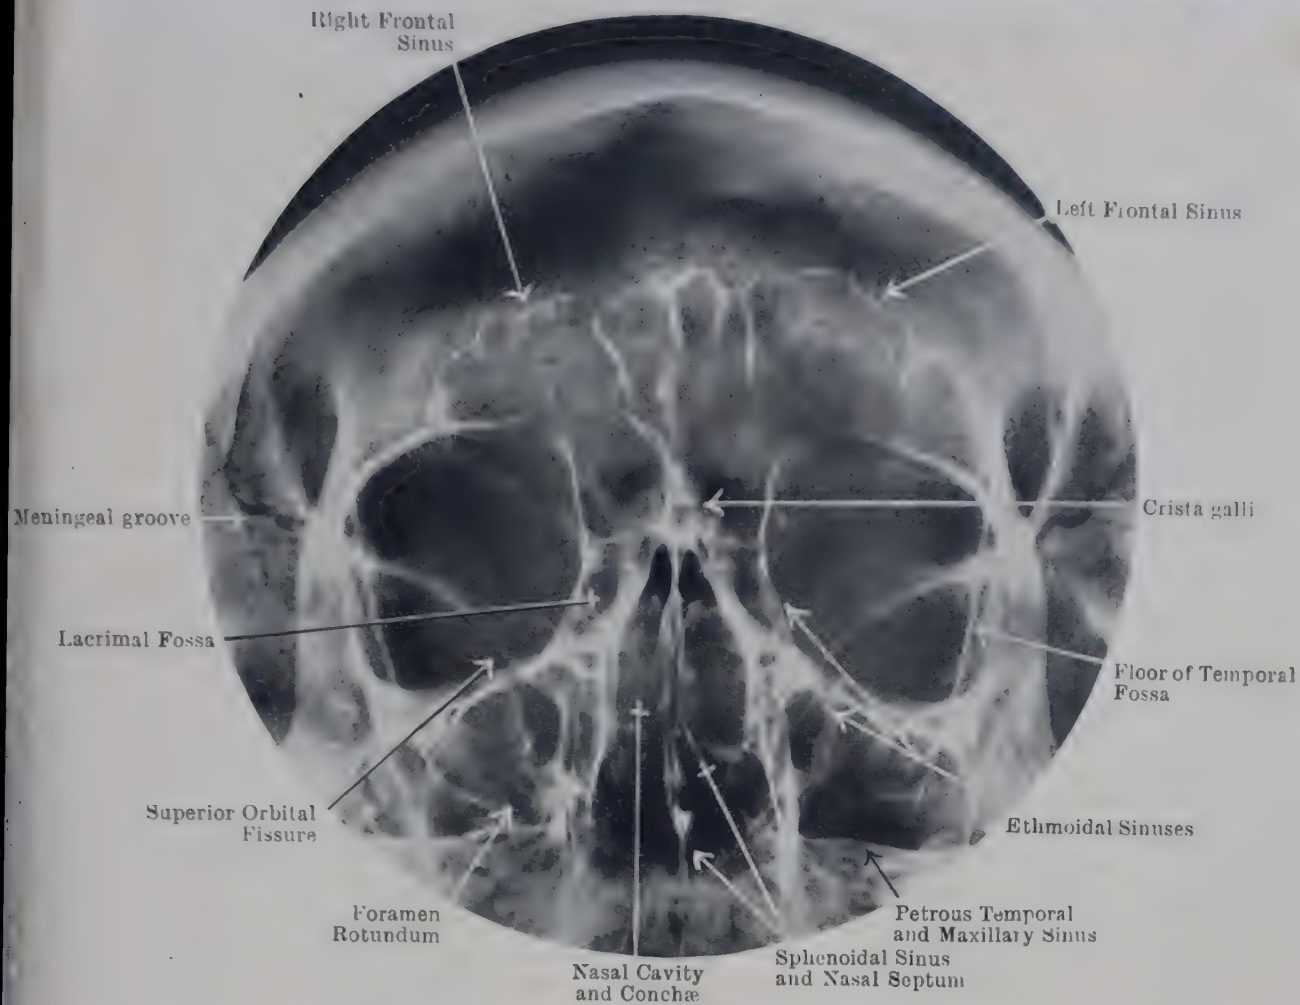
OCCIPITO-MENTAL RADIOGRAPH OF SKULL TO SHOW IN PARTICULAR THE EXTENT AND ASYMMETRY OF THE FRONTAL SINUSES.
